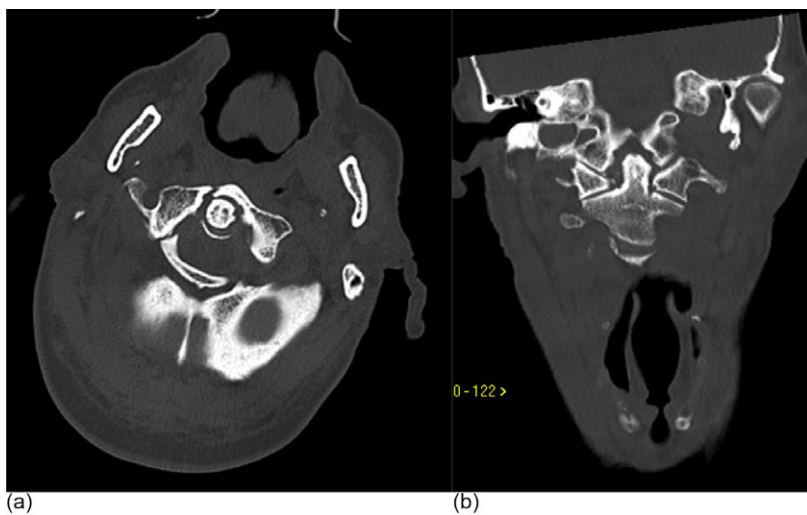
(a) Axial CT and (b) coronal reconstruction
